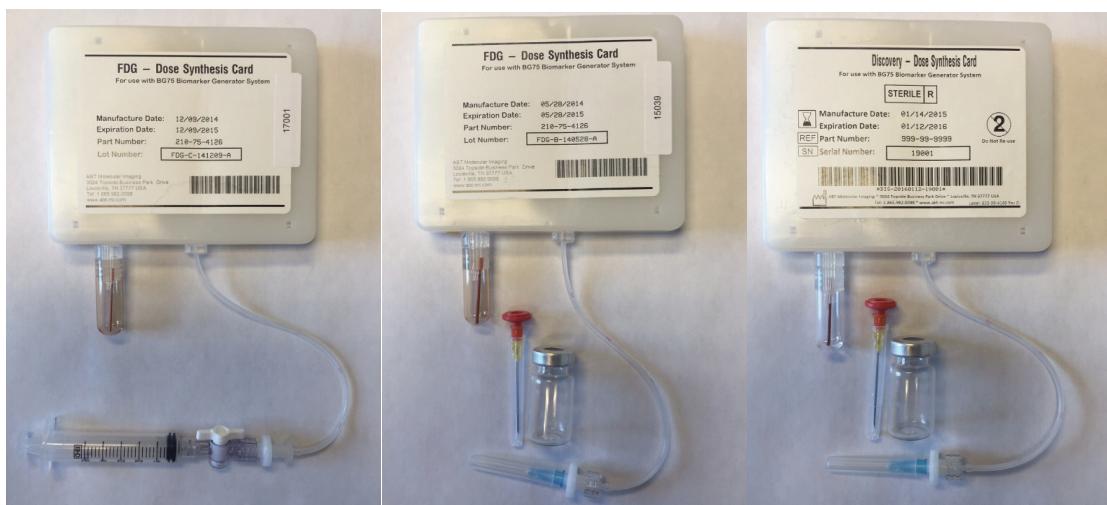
Dose Synthesis Cards (DSC) available for the BG75 1.0 Enhanced GMP system. (Left) [¹⁸F]FDG Enhanced GMP Syringe card for individual doses, (Middle) [¹⁸F]FDG Enhanced GMP Batch card that dispenses into a vial for dose splitting and (Right) Discovery Card that dispenses to a vial for HPLC purification.
